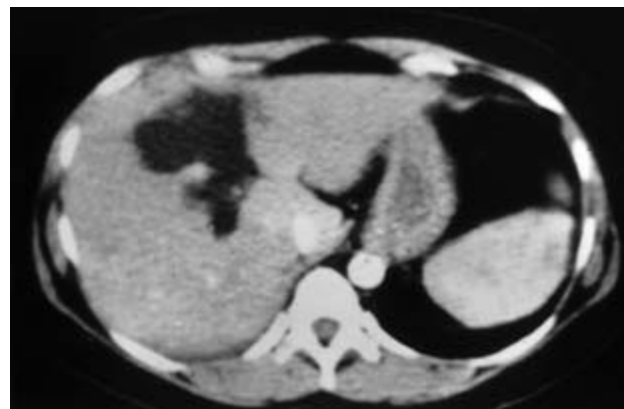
Focal fatty liver. CT scan shows a low attenuation filling defect in the right lobe of the liver. This lesion disappeared spontaneously.
